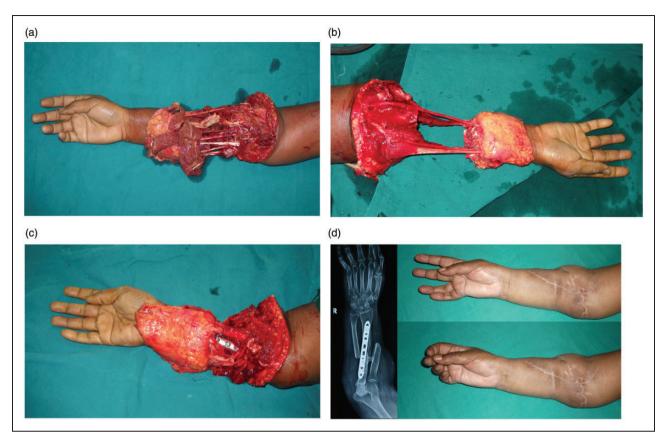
(a) Crush injury forearm following a road traffic accident in a 40-year-old diabetic lady with extensive contamination, segmental fractures and distal non-viability. (b) Post debridement picture. Median and ulnar nerves, extensor carpi radialis longus and slip of extensor digitorum communis were intact. (c) Creation of one bone forearm, with plating of proximal ulna to distal radius with excision of devitalized bone, revascularization with repair of radial, ulnar arteries and venae commitantes, cephalic vein and en masse repair of flexors and plication of intact tendons. (d) Postoperative radiograph showing union of bones with the hand capable of pinch and grip. The limb is shorter by 10 cm but not apparent at work.
